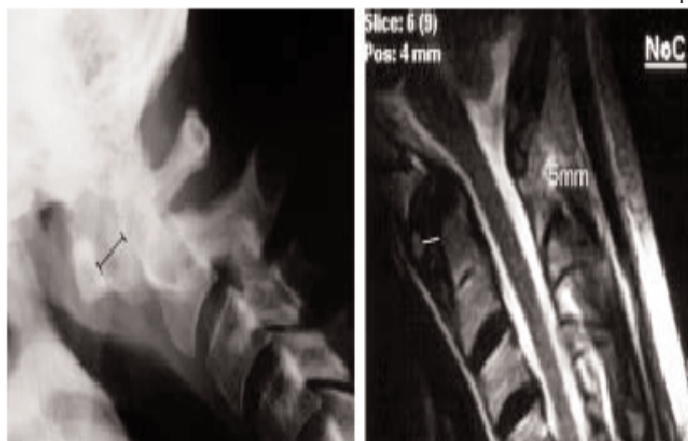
A 27-year old patient with a four years of RA. MR findings of the CS depicted anterior atlantoaxial subluxation (Magnetic resonance finding atlantoaxial distance flexion =5mm) while x-ray atlantoaxial distance flexion =8mm.
